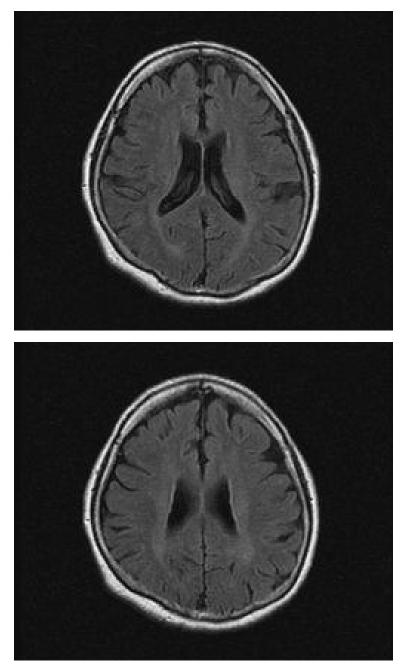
Brain magnetic resonance imaging on T2 weighted images obtained from a 77 year old female without cognitive impairment and being under medication for hypertension. These images show somewhat brain atrophy but no white matter hyperintensities.
